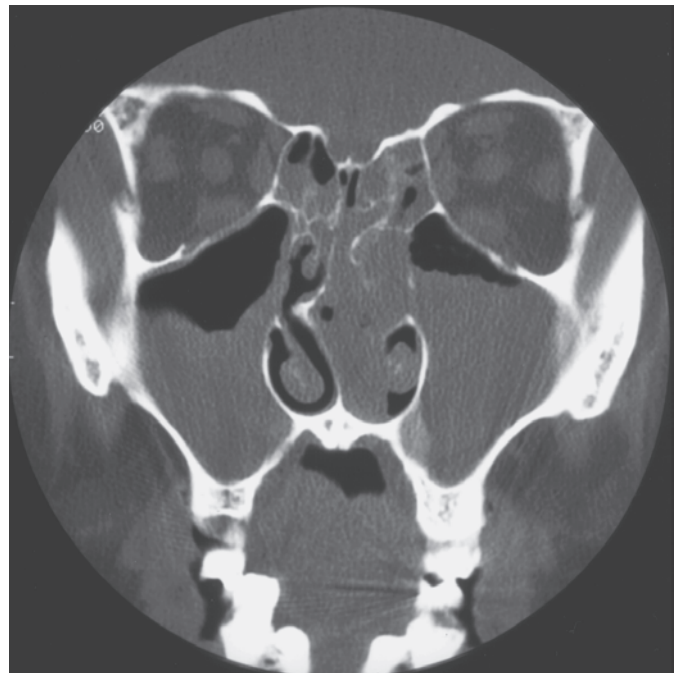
Sinus computed tomogram showing opacification of the osteomeatal complex on the left, subtotal opacification of the right maxillary sinus, and an air-fluid level in the left maxillary antrum.
